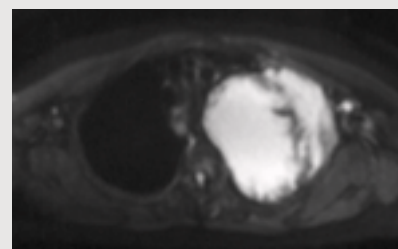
Diffusion-weighted image – DWI ($b = 50$)
